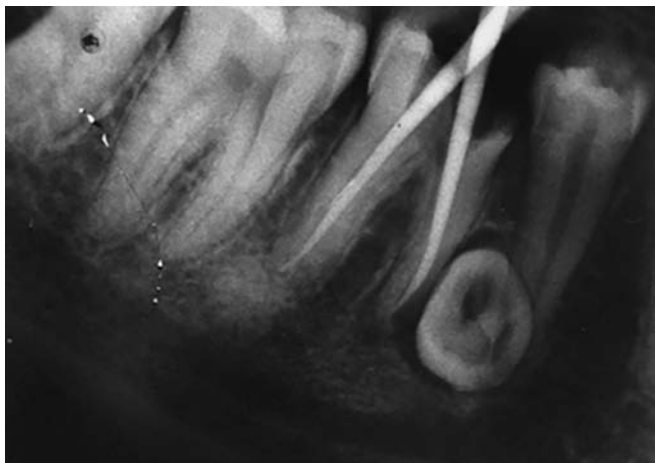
X-ray showing the fit of gutta-percha point
